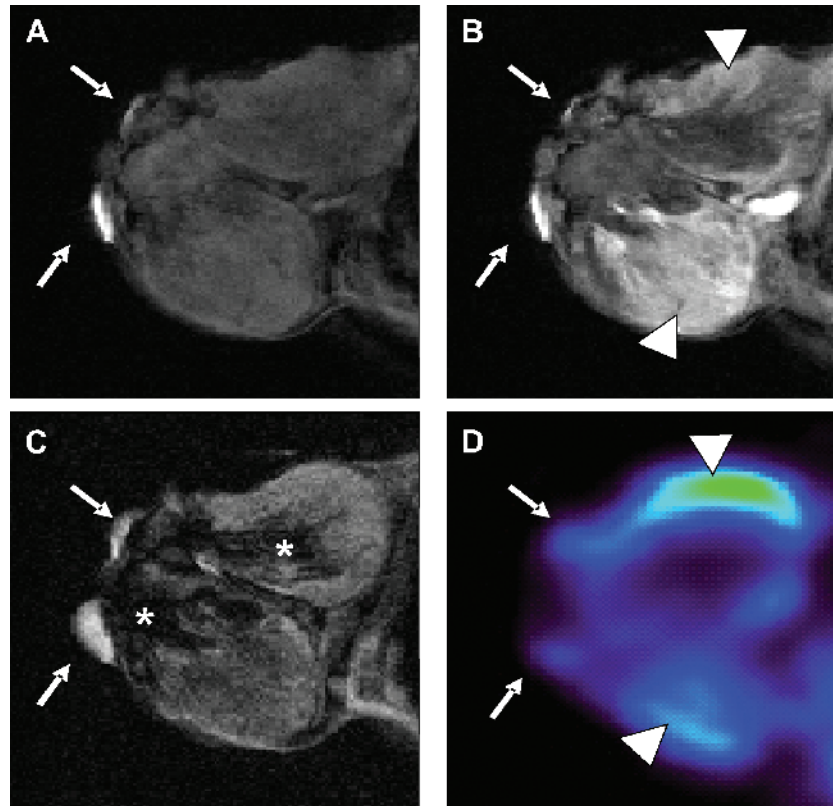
Mapping of perfusion and metabolic pattern on spontaneous carcinomas. Precontrast (A), early postcontrast (B), T_2 -weighted (C), and FDG-PET (D) corresponding sections of a spontaneous breast carcinoma. External reference points (white arrows) were used to obtain better alignment between MRI and PET scan. A large hemorrhagic necrotic area was appreciable in a T_2 image (asterisks), which did not enhance on postcontrast MRI and did not take up FDG. Viable tumor tissues evidenced areas of higher and lower FDG consumption (arrowhead) revealing, respectively, lower and higher Gd-DTPA enhancement.
